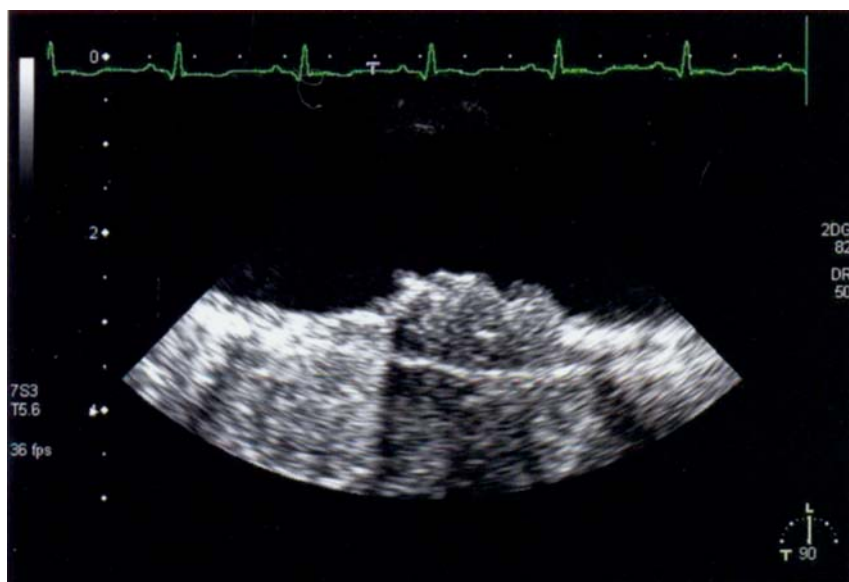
Transoesophageal echocardiographic longitudinal image of severe aortic sclerosis with protruding atheroma and beginning ulceration.
